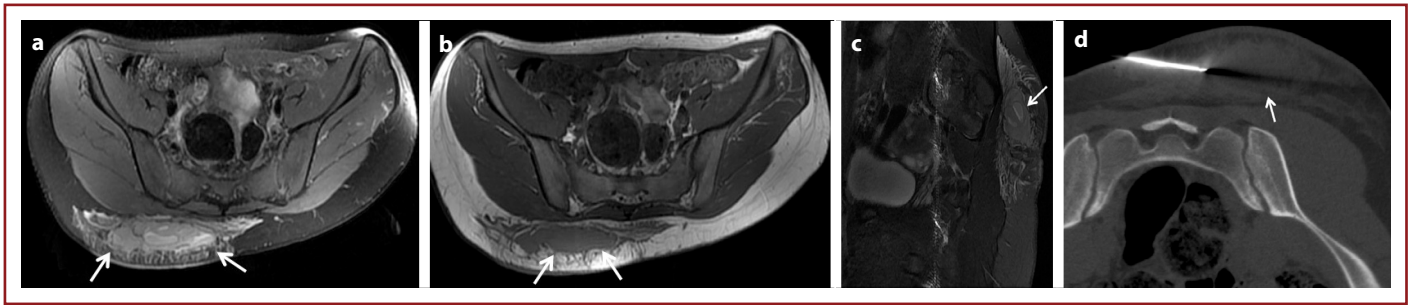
Case No 5: (a) Axial fat-suppressed FSE PD, (b) axial FSE T1, (c) sagittal fat-suppressed FSE T2 weighted images showing a heterogenous fusiform collection (slightly hyperintense compared to the muscle on T1 weighted image) with peripheral edema at the right gluteal region in association with deep fascia (white arrows). (d) Axial CT image showing thick spinal needle (black arrow) for the CT guided percutaneous aspiration procedure of the lesion (white arrow).
